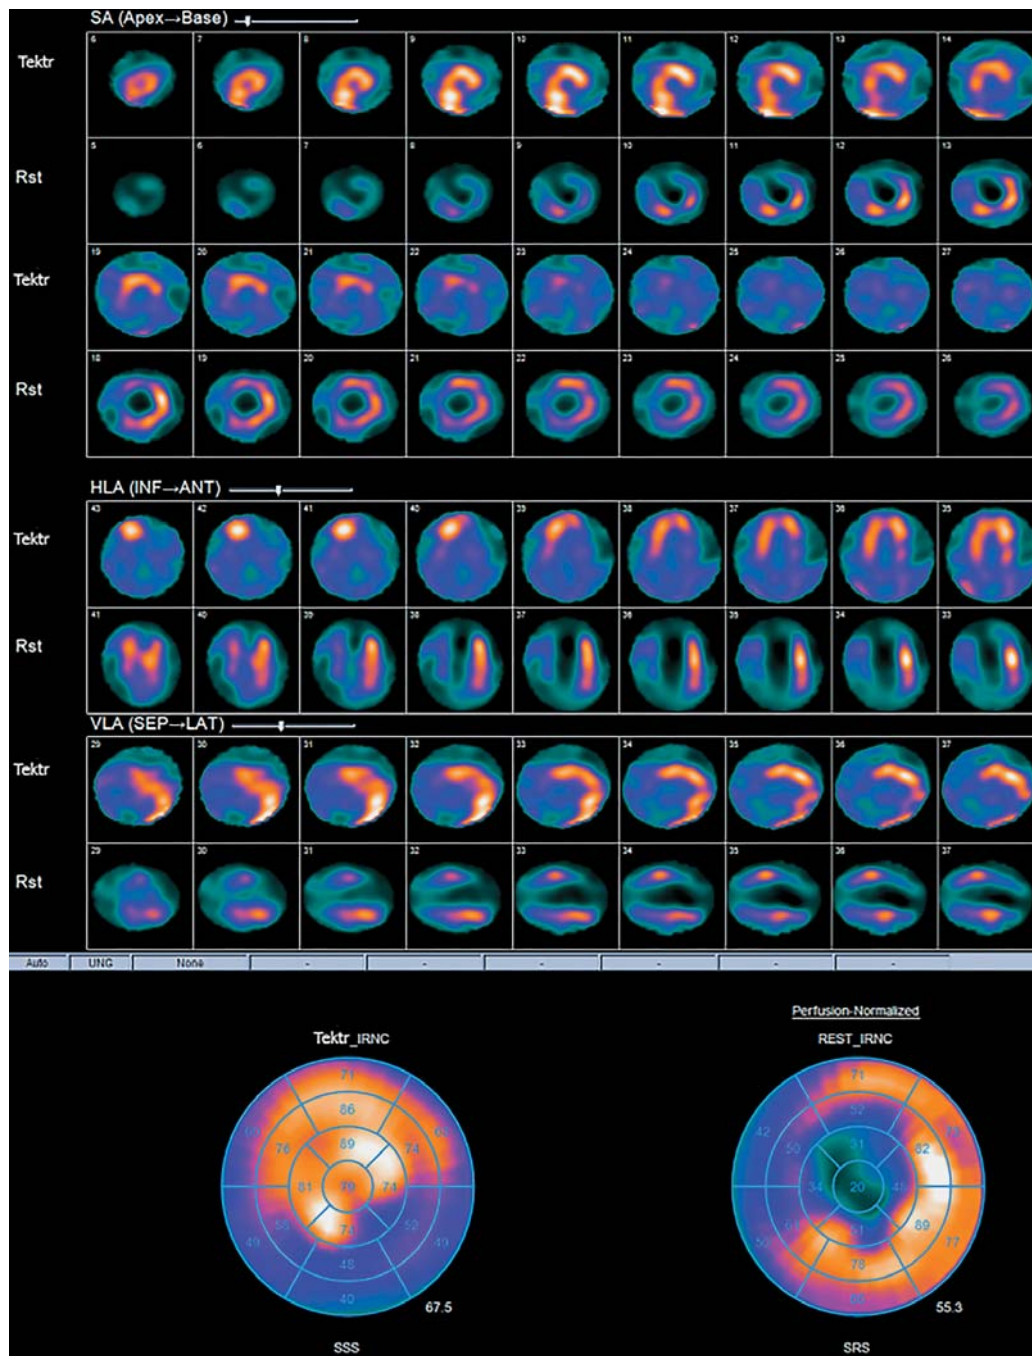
Cardiac ^{99m}Tc -Tekrotyd (Tektr), ^{99m}Tc -sestamibi SPECT images at rest (Rst) and their polar maps shows «mirror» accumulation of tracers in patient with old myocardium infarction.
